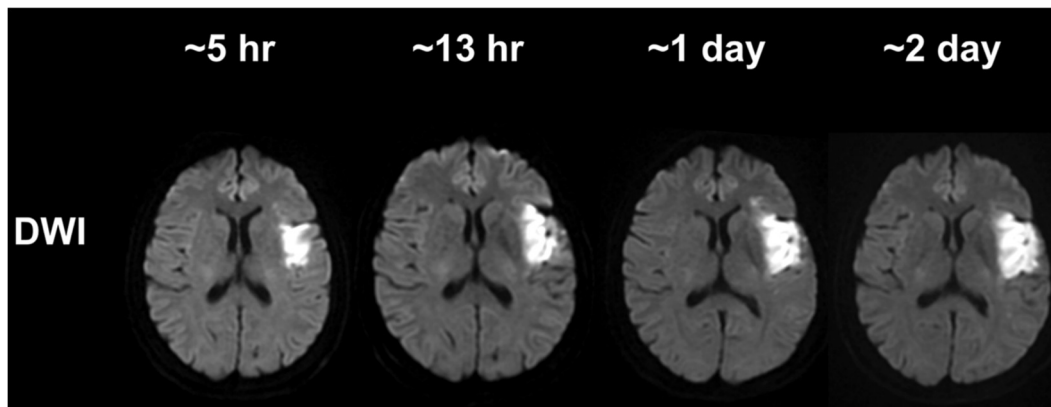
Brain changes after a stroke imaged with MRI [9]. (Modified with permission)
